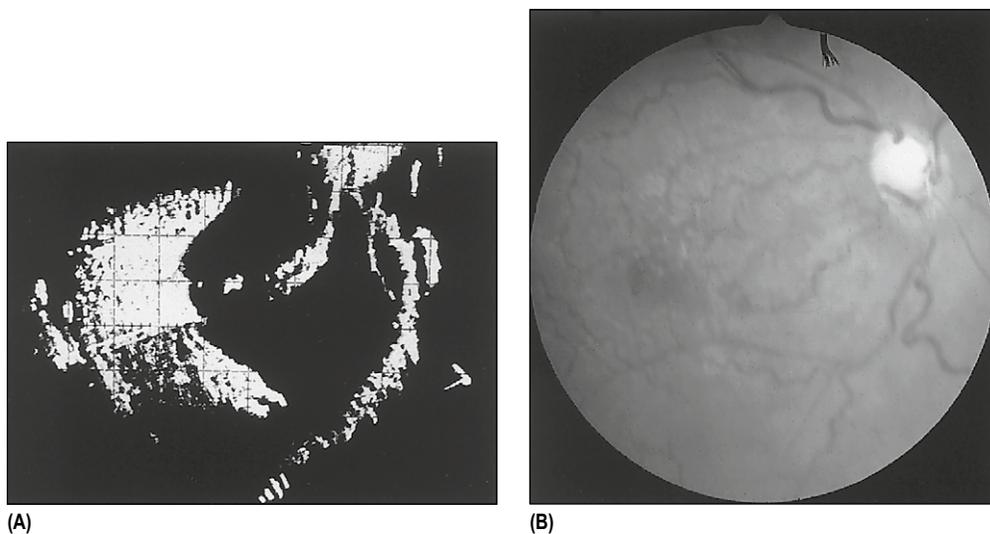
(A) On opening this eye for trabeculectomy, the anterior chamber collapsed and could not be reformed by injection of balanced salt solution. The flap was closed. Postoperative ultrasonography revealed this large choroidal elevation extending almost to the optic nerve posteriorly. (B) Serous retinal detachment overlying choroidal expansion in a Sturge-Weber patient following postsurgical choroidal expansion. There was no retinal hole in this patient and the detachment resolved spontaneously.
